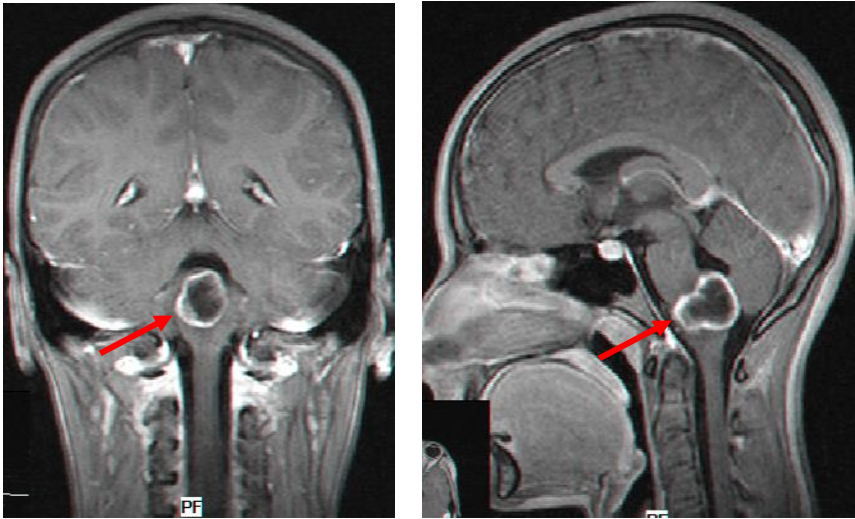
MRI examination in coronal and sagittal section of a bulbo-pontine infiltrative glioma (Personal collection of Prof. Dr. Stefan Ioan Florian)
